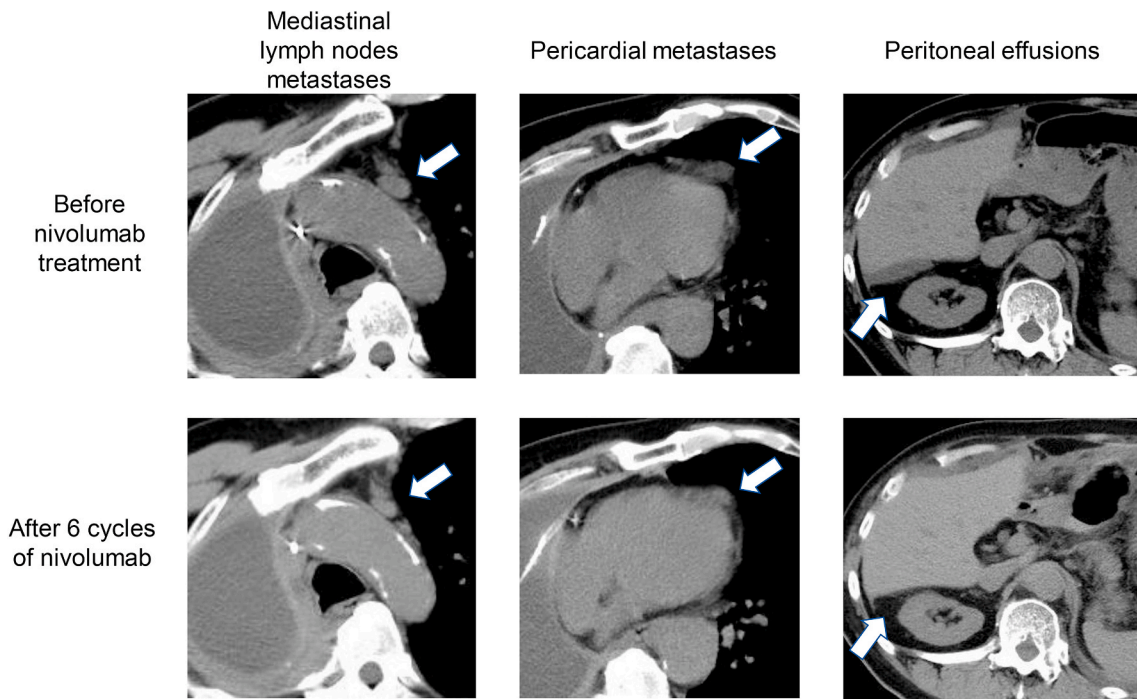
Computed tomography images of mediastinal lymph nodes, pericardial metastases, and peritoneal effusion before and after treatment with nivolumab. Shrinkage of mediastinal lymph nodes and pericardial metastases and a decrease in peritoneal effusion were observed after nivolumab administration.
